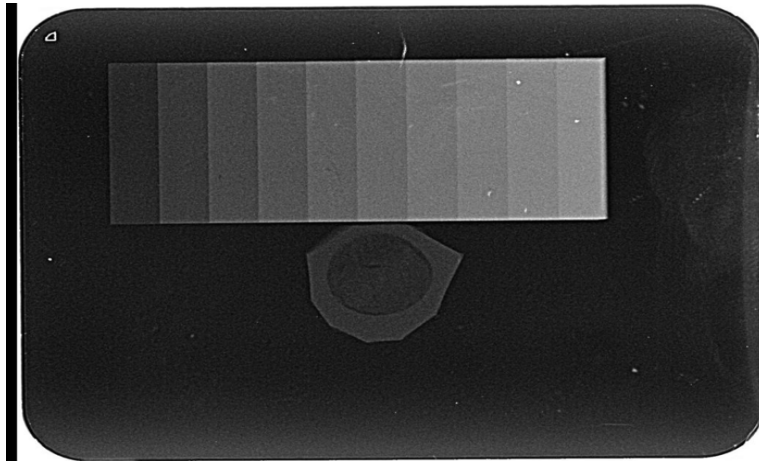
Radiograph of a sample with an aluminum scale positioned on an occlusal radiographic film.
